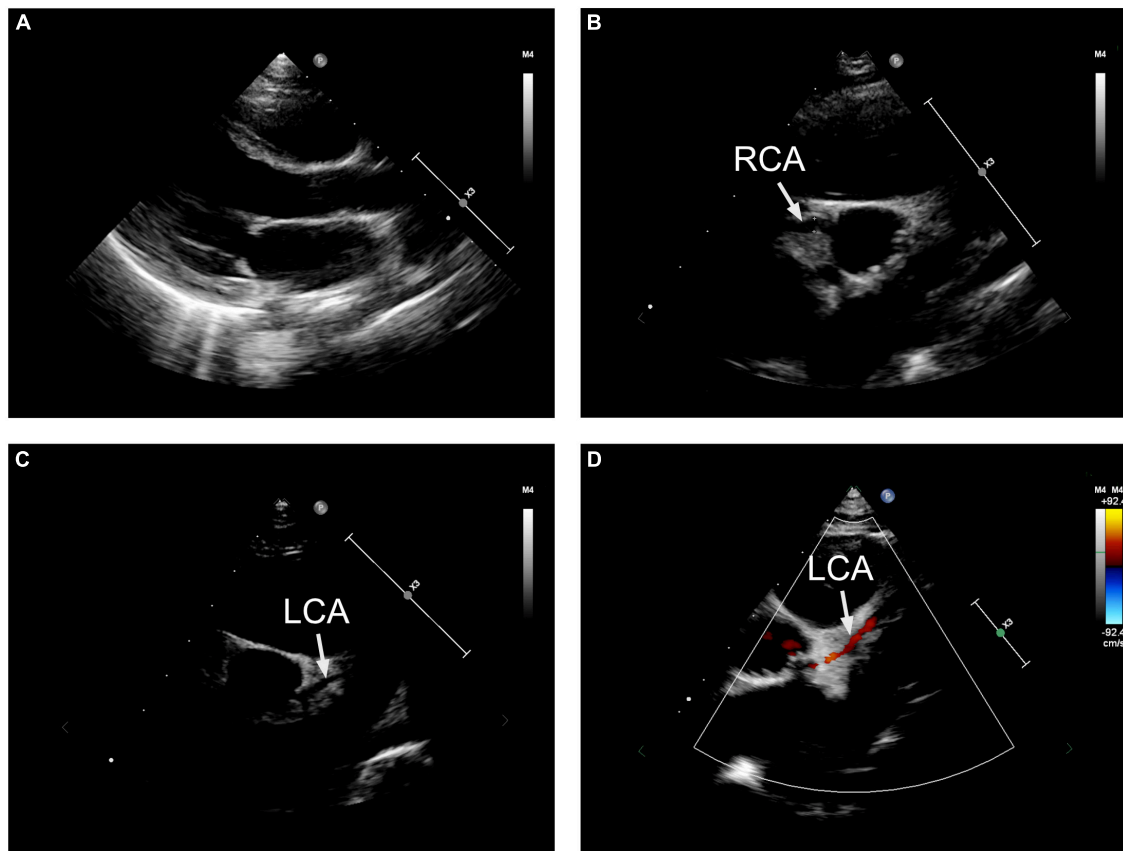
The echocardiographic presentation. (A) Left ventricular ejection fraction (LVEF) decreased dramatically to 23%. (B) The right coronary artery presented clearly with normal formation and lumen diameter. (C) The origin and course of the left coronary artery seemed to be normal, with a related narrowed lumen diameter. (D) Doppler demonstrated a non-continuous blood flow in the left coronary artery. RCA, right coronary artery; LCA, left coronary artery.
